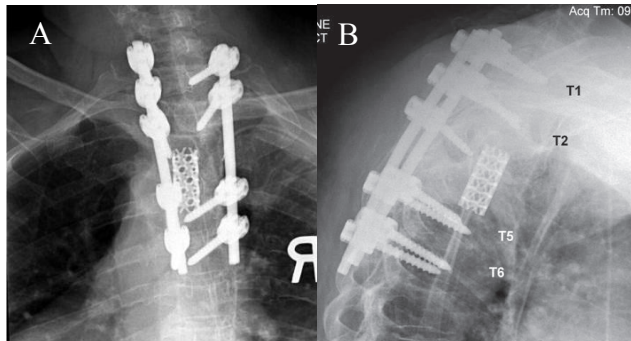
Immediate postoperative images. AP (A) and lateral (B) radiographs show placement of a titanium cage anteriorly spanning the T2 inferior endplate to the T5 superior endplate. Posterior instrumentation in the form a pedicle screw and rod construct from T1 to T6 is likewise evident. Kyphotic angle from T1 to T6 is 20 degrees.
